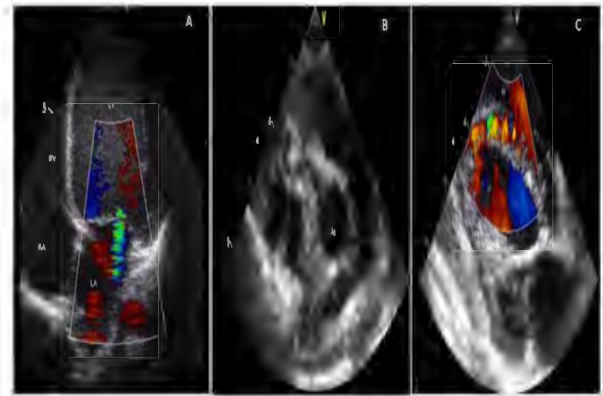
A. Mild to moderate mitral regurgitaion with dilated left ventricule, B. The right coronary artery was shown to be originated from aorta and it was larger than normal. But the origin of the left coronary artery was not clear, C. Color doppler echocardiography showing the colletaral circulation through the interventricular septum.
